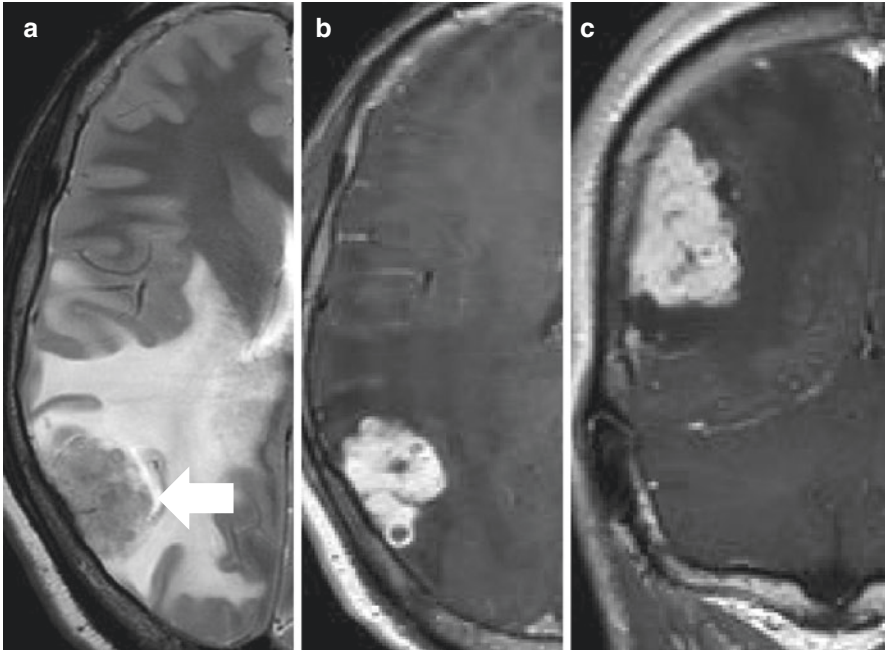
Durally based tuberculosis infection. There is an extra-axial durally based lesion which is hypointense on T2-weighted images (a, arrow), and demonstrates avid contrast enhancement on axial (b) and coronal (c) post-contrast T1-weighted images. Also note the extensive surrounding oedema, best seen on the T2-weighted imaging (a)
